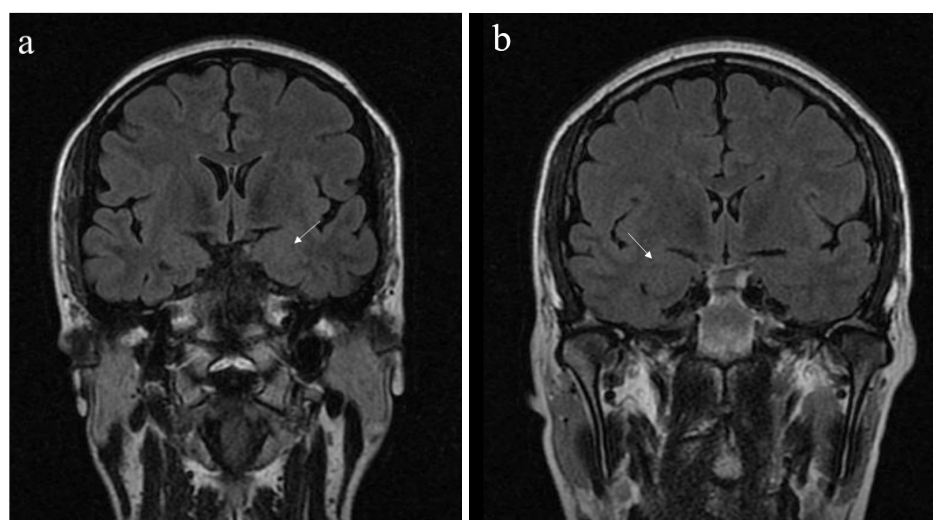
Coronal Flair MRI images in TLE-AE patients. (a) The arrow indicates a representative image of left AE in Case 12. (b) The arrow indicates a representative image of right AE in Case 5.
